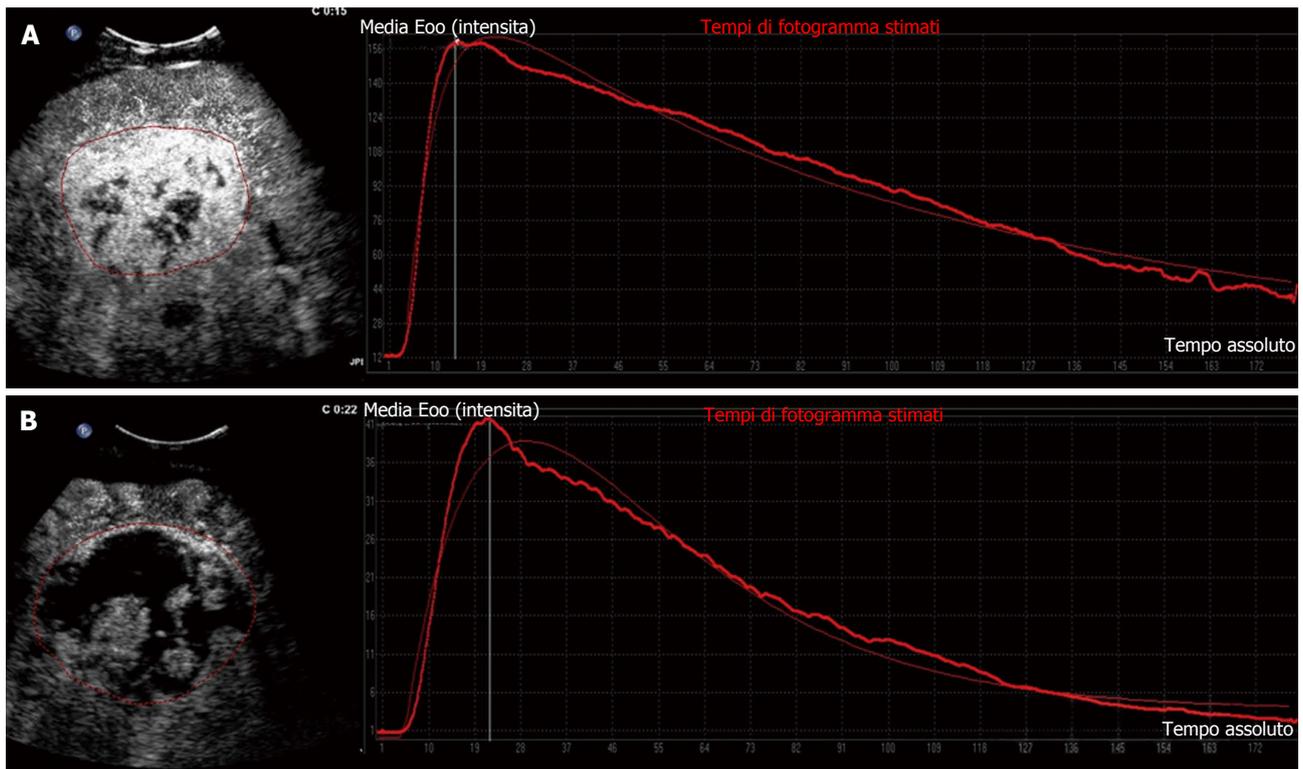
Target hepatic lesion in a 65-year-old man treated with sorafenib: Clinical example of responder on dynamic contrast-enhanced ultrasound. A: Contrast-enhanced ultrasound with corresponding time-intensity curve at baseline; B: Fifteen days after onset of sorafenib therapy, contrast-enhanced ultrasound revealed an increase in tumour necrosis with drastic reduction of tumour perfusion parameters shown by contrast enhancement pattern and corresponding time-intensity curve.
